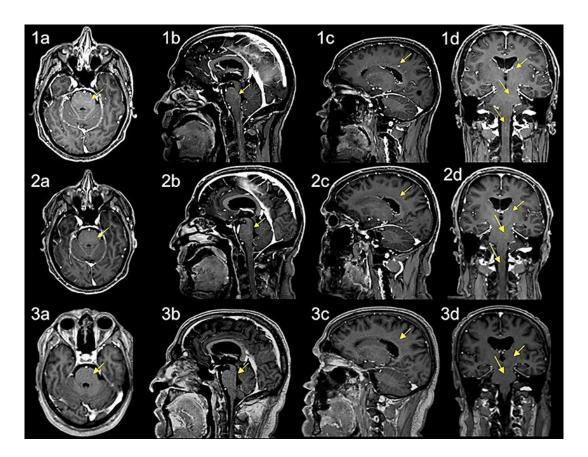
Brain MRI scan at admission, after 1 week of steroid therapy, and after 1 month of steroid therapy. Gd-enhanced MRI scans of the brain. The arrows indicate the main sites of the widespread pattern of perivascular dot-shaped and curvilinear enhancement, mostly within the pontocerebellar region, but also surrounding the lateral ventricles. Also, central spinal enhancement can be observed. The scan on the first line was acquired before the therapy. The scan on the middle line was obtained after 1 week of high-dose steroid therapy. The scan on the lower line shows complete resolution of the picture after 1 month of steroid therapy. First column (a), axial section; second and third column (b, c), sagittal sections; fourth column (d), coronal section.
